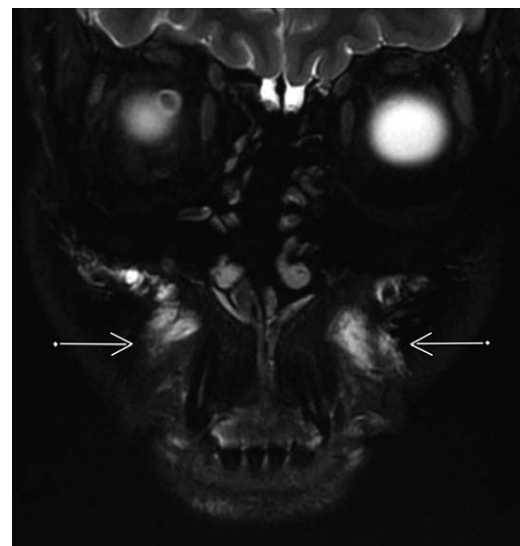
Coronal T2-weighted fat saturation 3-T magnetic resonance imaging scan obtained using a GE Pioneer magnetic resonance imaging. *Arrow* indicates the hyaluronic acid signal within the nasolabial fat pads.
